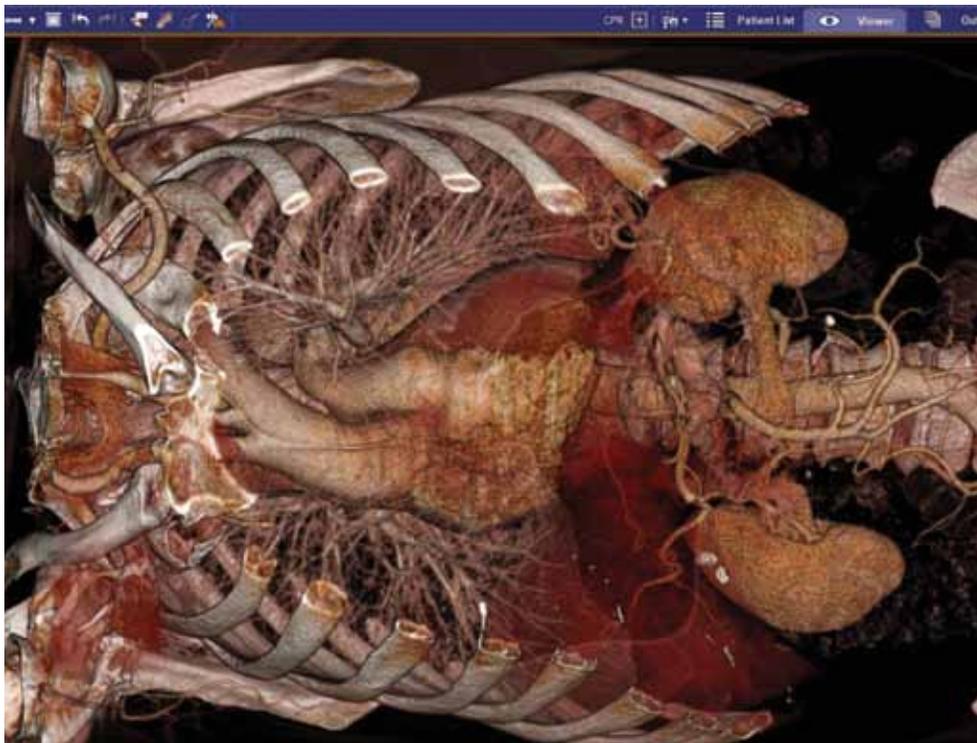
Looking down on the 36 in x 42 in multi-user virtual surgical table in Plato's CAVE using Siemens flash low-dose CT scan patient data with TeraRecon, Inc.
